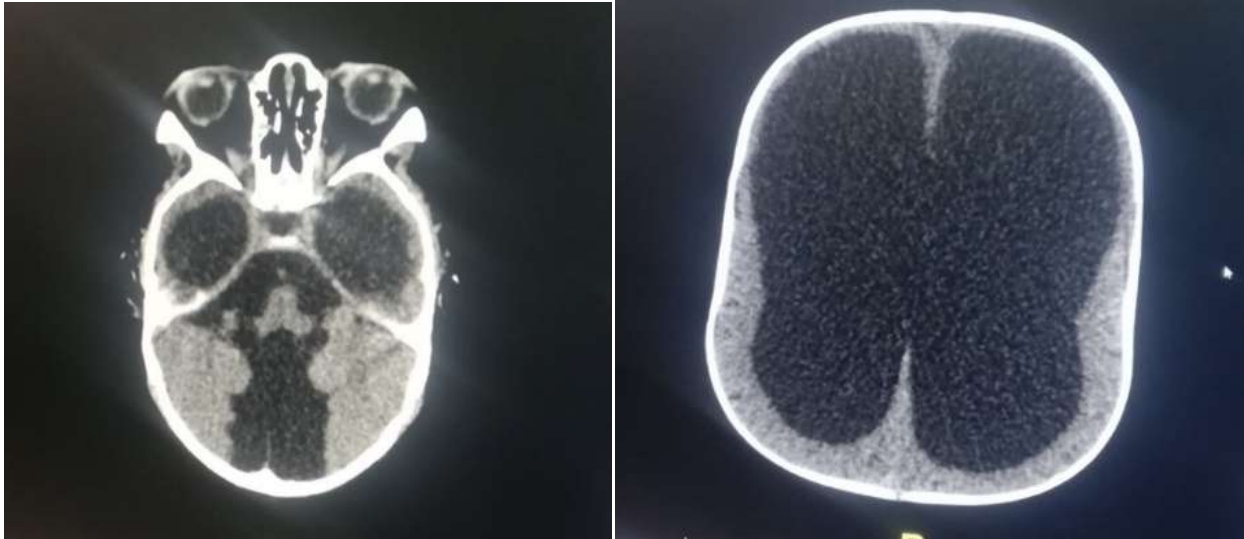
Axial CT section without IV of PDC showing partial agenesis of the vermis associated with a cystic formation of the posterior fossa communicating with V4 responsible for supratentorial hydrocephalus suggesting: a true Dandy Walker malformation.
